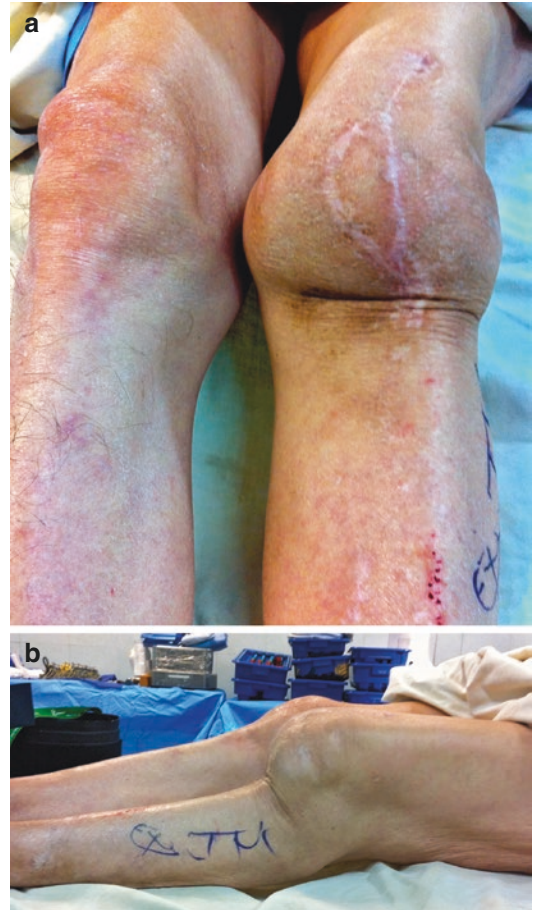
(a, b) Clinical and (c) radiographic appearance of a 66-year-old patient with a chronically dislocated left TKR. This patient dislocated the first time 6-week post-op and underwent two more unsuccessful surgeries. He was in a wheelchair for almost 3 years. (d) Postoperative X-ray after open reduction, extensive lateral release, and medial reefing. The components were not loose, and there was no possibility of revision to a constrained configuration. The patient was immobilized in a cylinder cast in extension for 3 months and is still able to bear full weight at 2 years in a knee brace, but without any knee motion
